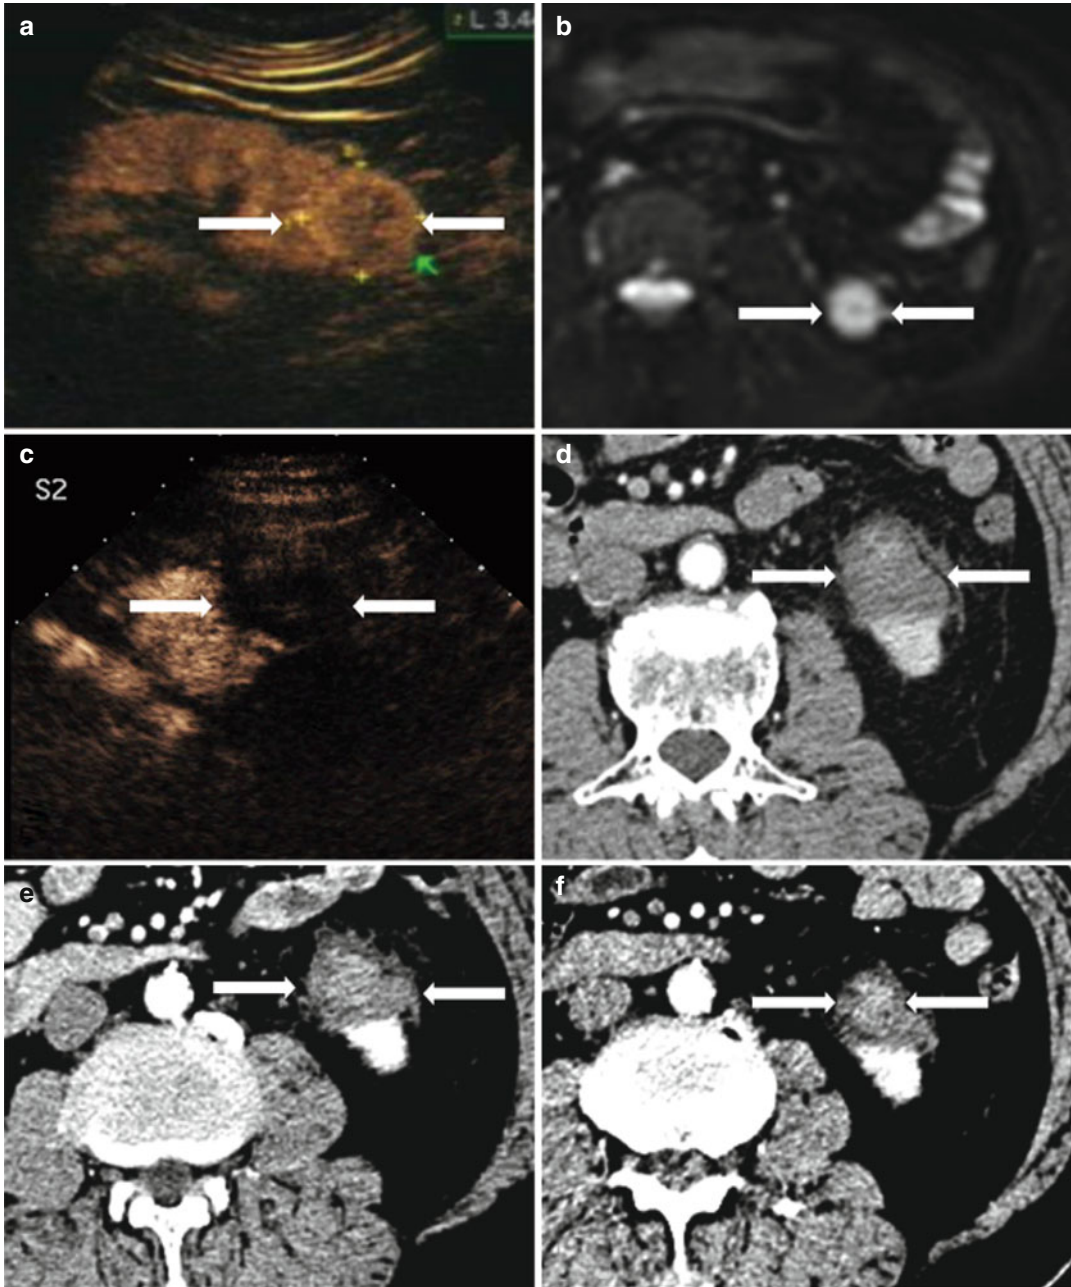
Images in a 73-year-old female with a RCC (3.4 cm×3.4 cm) in the left kidney treated with MWA. (a) Pre-ablation contrast-enhanced CEUS shows a hyper-enhancement in cortical phase. (b) MR imaging showed one hyper-intense lesion exophytically in the inferior pole of the kidney (arrow) on T2 image. (c) Three days after
